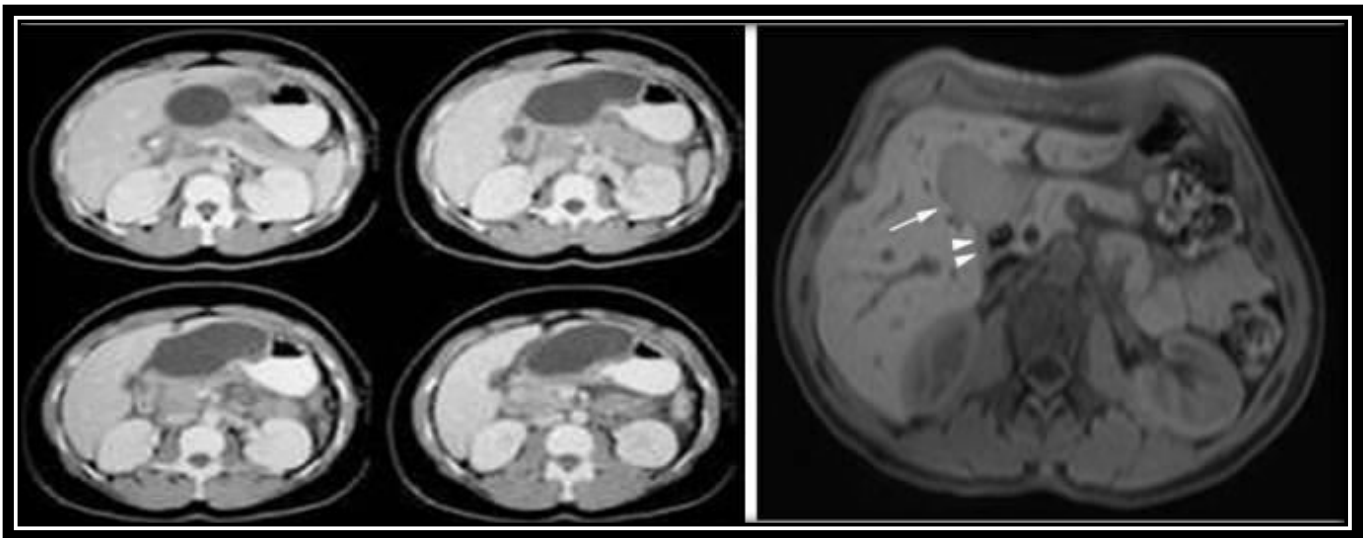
Post cholecystectomy leakage and biloma collection as seen by CT (left) and MRI (right)
